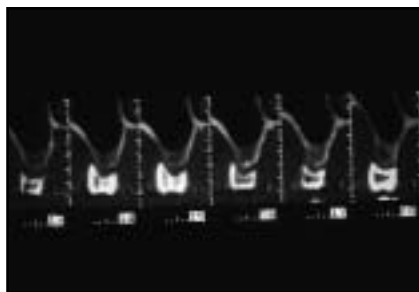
Each patient underwent CT examination with a diagnostic paraxial stent. This made it possible to determine the correct position of the bony window and measure the thickness of the lateral sinus walls.
